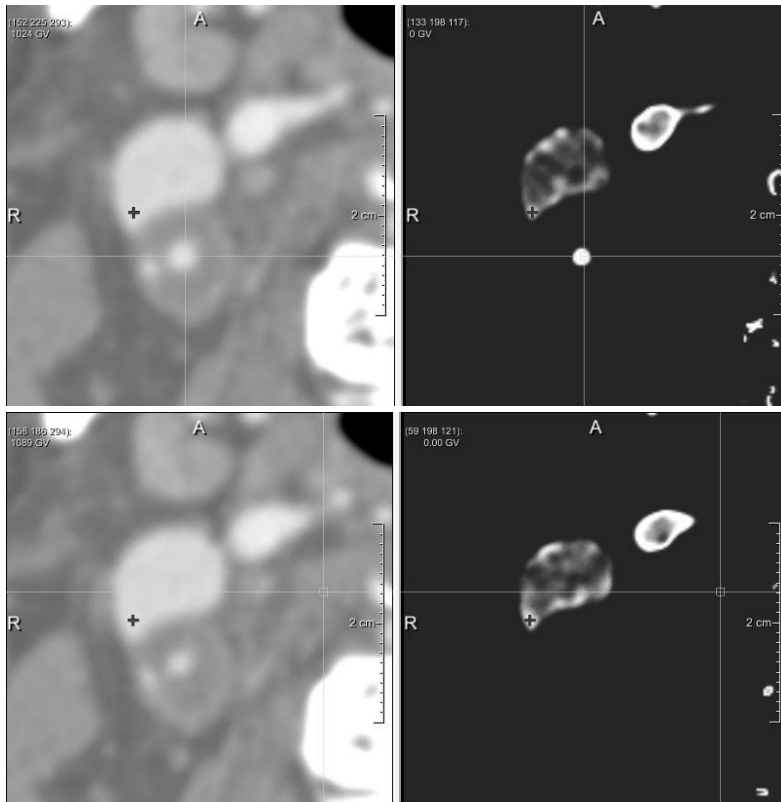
Axial consecutive slices of carotid artery CTA scan with high stenosis (left), corresponding intensity-range images $P(I(x))$. Crosses represent initial centerline points erroneously positioned in jugular vein.
